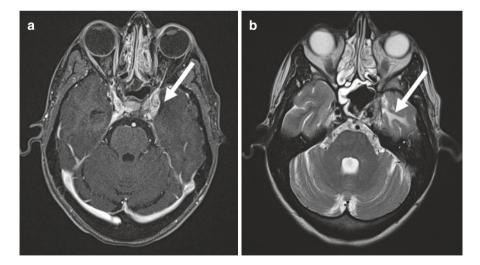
Gadolinium-enhanced T1-weighted magnetic resonance imaging (a) demonstrating enhancing thickening along the mandibular branch (V3) of the trigeminal nerve, conditioning lateral bulging of cavernous sinus dural membranes (arrow). On T2W image (b), brain edema is present due to mass effect of the cavernous sinus bulging
